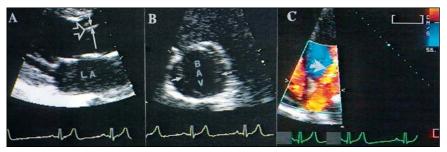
Transthoracic echocardiogram of a 17-year-old male patient with a congenital bicuspid aortic valve presenting as isolated aortic regurgitation. The parasternal long-axis view (A) shows eccentric closure (open, short arrow) of the aortic valve due to unequal length of the leaflets (thin arrows); the parasternal short-axis view (B) shows the aortic root, which contains an open bicuspid aortic valve; and the modified apical four-chamber view (C) focuses on the aortic regurgitation jet (short, closed arrow). Abbreviations: BAV = bicuspid aortic valve; LA = left atrium.
